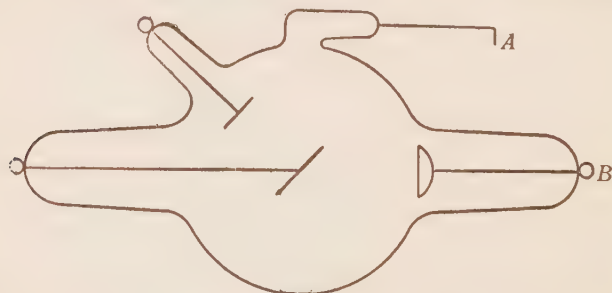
Represents a self-regulating X-ray tube. When adjusted for a certain parallel spark gap, if its resistance becomes higher than the parallel spark gap it was set for, the spark will pass between "A" and "B" so that the current is conducted into the small extension tube having a chemical which, when the electricity passes through it, gives off a gas which lowers the resistance of the tube. When using the tube as a pointer, as shown on Fig. 37, it is necessary to turn the current off and keep moving the pointer "A" a little closer or a little further away according to the desired regulation of the tube. When, however, the tube is connected as shown by Fig. 46, then the operator does not have to shut off the current, as the spark gap is adjusted by raising or lowering the rod "E" of the middle spark gap.
